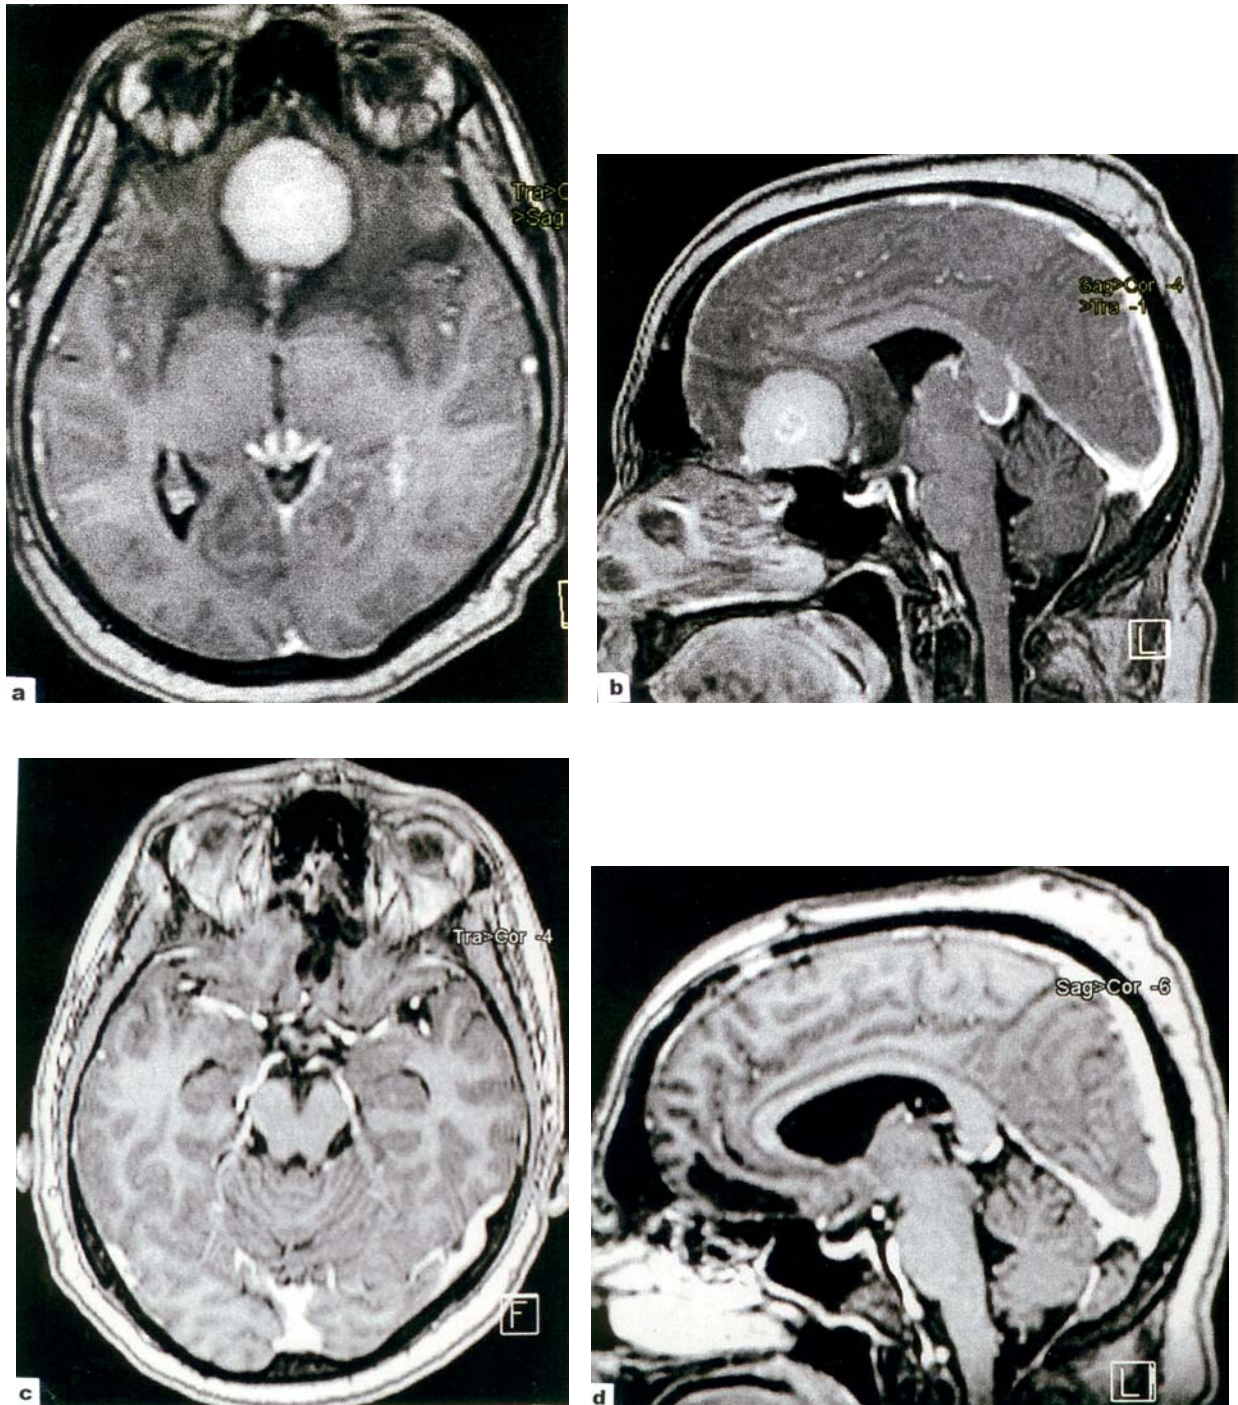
An olfactory groove meningioma in a 49-year-old woman who, besides several moderate characteristic disorders caused by the compression of the orbital prefrontal cortex, had also presented the degradation of the sense of pudency. The magnetic resonance imaging (MRI) examination reveals an olfactory groove meningioma with bilateral extension (a and b), which had been surgically resected in its entirety (c and d). The symptomatology had disappeared after the surgical treatment (surgeon Leon Danaila).
